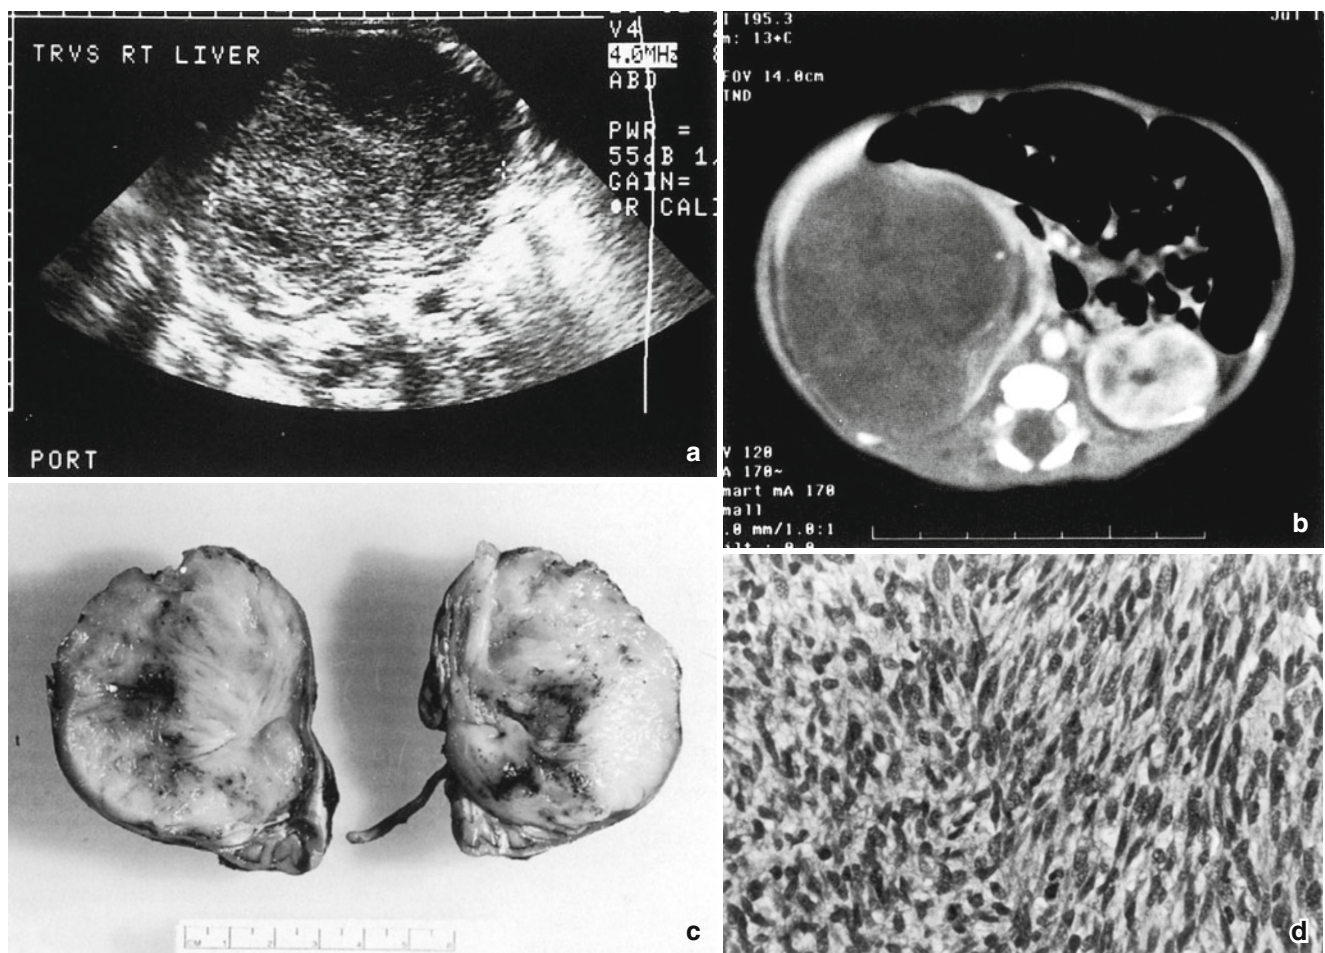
Congenital cellular mesoblastic nephroma. (a) Sonogram shows a right abdominal mass. (b) CT scan reveals a large mass replacing most of the kidney. (c) The tumor, 122 g and 6.5×5.5 cm, has a white-yellow, gelatinous cut surface with foci of hemorrhagic necrosis. It occupies almost the entire kidney except for a small portion of renal
